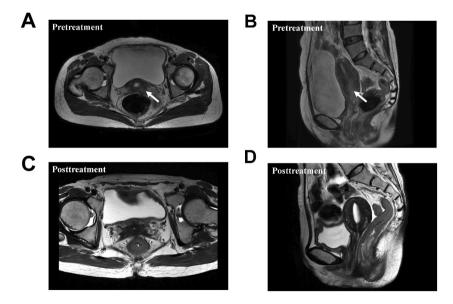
(A) and (B) Pelvic MRI images before treatment. Irregular T2 slightly high signal shadow can be seen on the upper end of the cervix and vagina, the boundary of the lesion is unclear, and the range is about 50*23mm (White arrow). (C) and (D) Pelvic MRI images 2 months after the treatment. The slightly longer T2 signal of the cervix and upper vaginal end was significantly reduced. Axial image (A) and (C). Sagittal image (B) and (D).
